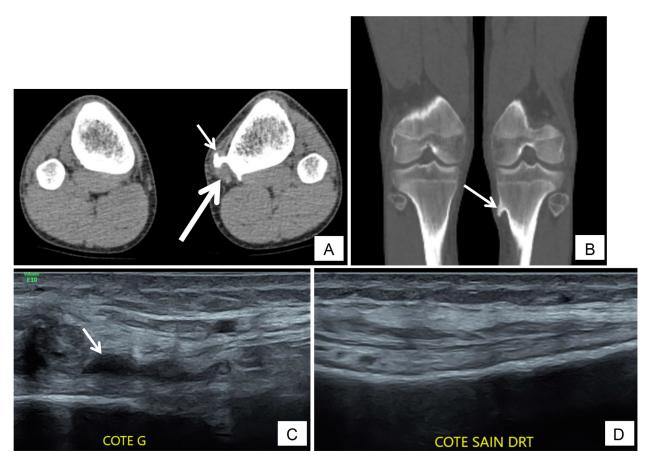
(A-D) – Computed tomography, with axial (A) and coronal views (B), showing a well limited and pedunculated bony outgrowth (arrow on A and B), at the expense of the internal side of the left proximal tibia metaphysis. It was located near the insertion of the pes anserinus tendon, associated to an infiltration of the soft tissues here (large arrow on A). An additional ultrasonography was subsequently done, on the affected side (C), and the normal leg (D), showing a thickened appearance of the tendons, coming into contact with the bony exostosis, with a small effusion of the peritendinous bursa at this level (arrow).
